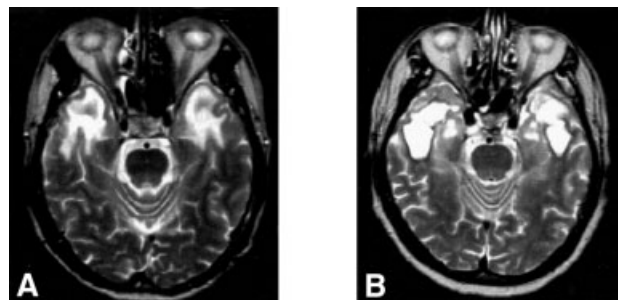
Radiation-induced lesions shown on magnetic resonance images. (A) T2-weighted horizontal image from a patient with nasopharyngeal carcinoma showing finger-like edema in the bilateral temporal lobes (B) T2-weighted horizontal image showing cysts in the bilateral temporal lobes.
